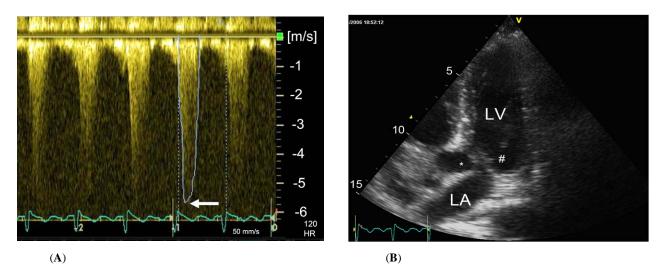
(1A) During hypovolemia and positive inotropic treatment: The peak pressure gradient measured with continuous wave Doppler in left ventricular outflow tract was 149 mm Hg (arrow) and a mean pressure gradient of 39 mm Hg. The left ventricular cavity was diminished. (1B) Systolic anterior motion of both anterior (*) and posterior (#) mitral valve leaflets is well appreciated.
